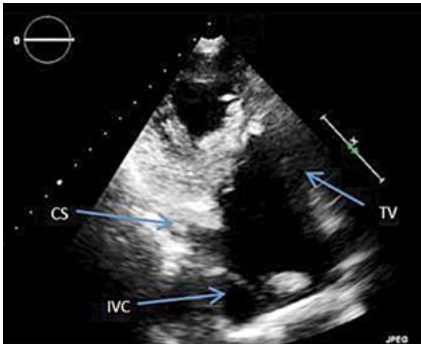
2D echocardiographic image of the right ventricular inflow tract (CS – coronary sinus, IVC – inferior vena cava, TV – tricuspid valve)
